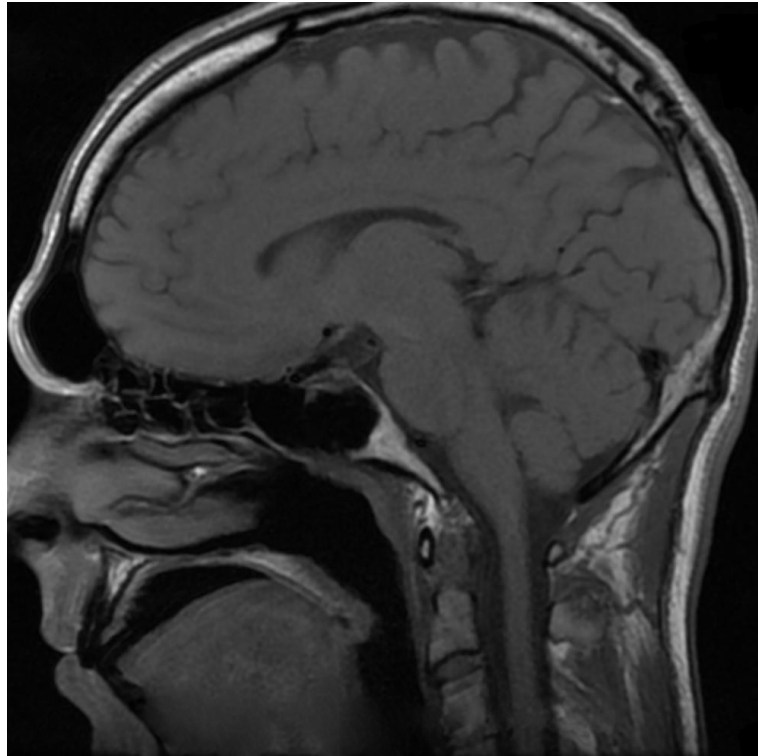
Magnetic Resonance Image of a Human Head
